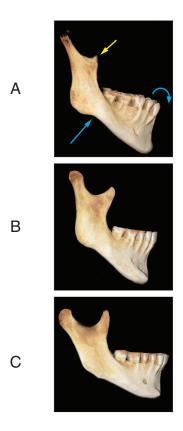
Lateral view of the mandible comparing coronoid processes. 3D CBCT reconstructions show the right mandibular view of (A) NM, (B) matched open bite and (C) matched control patients. Note the hypoplastic coronoid process in the NM patient (yellow arrow). Also note the clockwise rotation of the mandible (blue curved arrow) and the prominent anti-gonial notch (blue straight arrow) in both the NM, which is present but smaller in the matched open bite patient and is absent in the match control patient.
